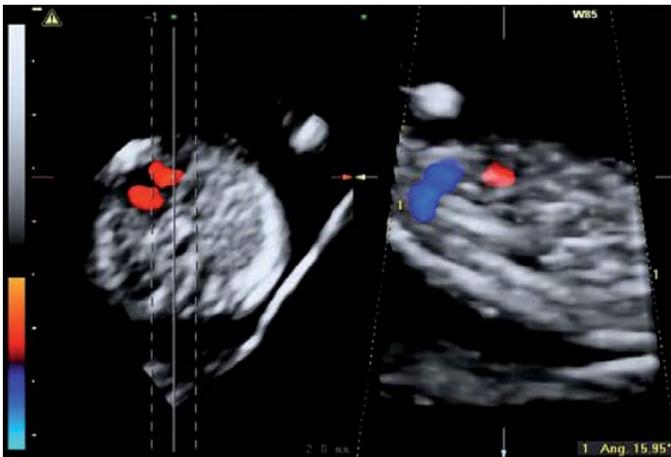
Tomographic ultrasound image (TUI) of a 12 week 3 day fetal heart using 2nd trimester technique of a 15 degree angle. On the left is the A plane which was the acquisition plane in an axial view. On the right is the reconstructed B plane seen in a sagittal view, 90 degrees from the A plane. The pictures clearly show how small the fetal heart is in relation to the size of the whole volume. Notice how much unnecessary captured data is seen around the fetal heart especially in the B plane.
